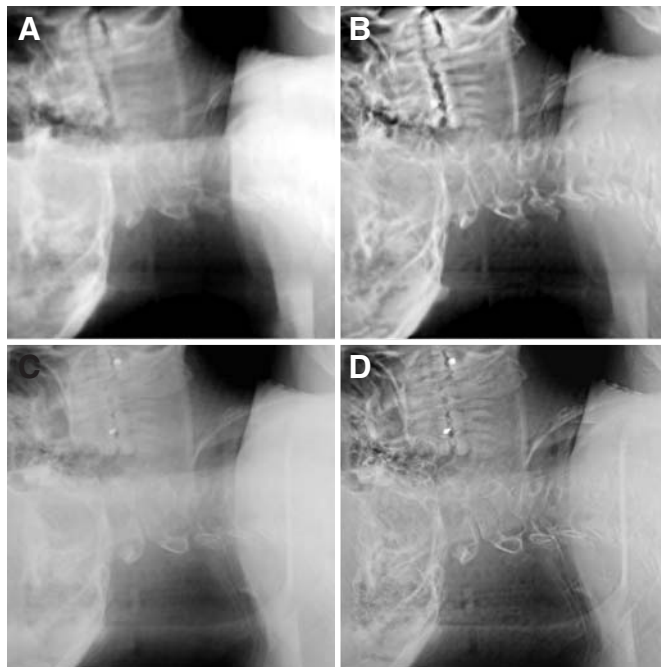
The effect of image enhancement for a cervical spine patient. A, original digitally reconstructed radiograph image, which is a synthetic x-ray image generated by casting rays through the CT scan using the known x-ray camera geometry. B, DRR image after image enhancement. C, original x-ray projection image. D, x-ray image after image enhancement. Image enhancement emphasizes the skeletal structures in the images and improves the estimate of local displacements of skeletal structures during the 2D-2D registration between an x-ray image and the corresponding DRR image.
